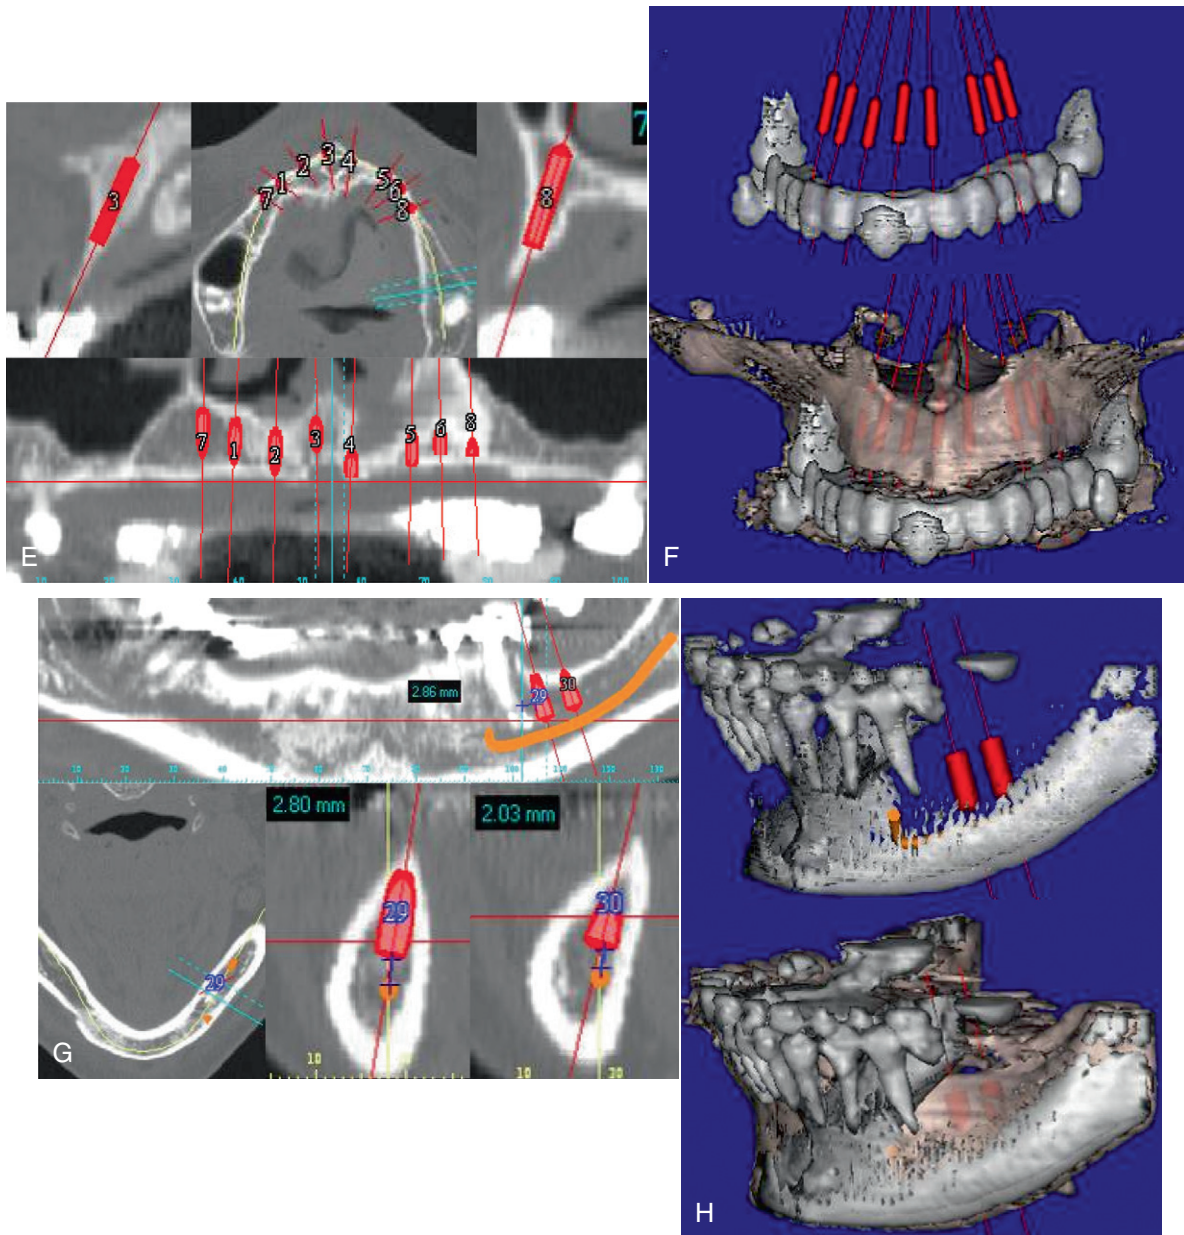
cont'd E, The pre-operative maxillary computed tomography (CT) scan showing all three views. F, The CT scan view of maxilla with proposed implant placement. G, The pre-operative mandibular CT scan shows the three dimensional views that facilitate treatment planning. H, The CT scan shows mandible with proposed implant placement.
